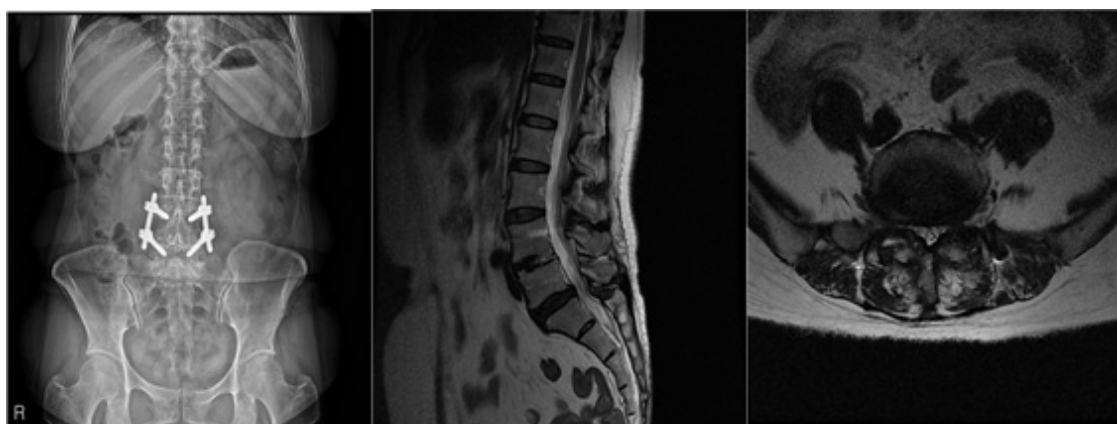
2014/03/22, Lumbar x-ray ap, sagittal image, L5-S1 axial image
